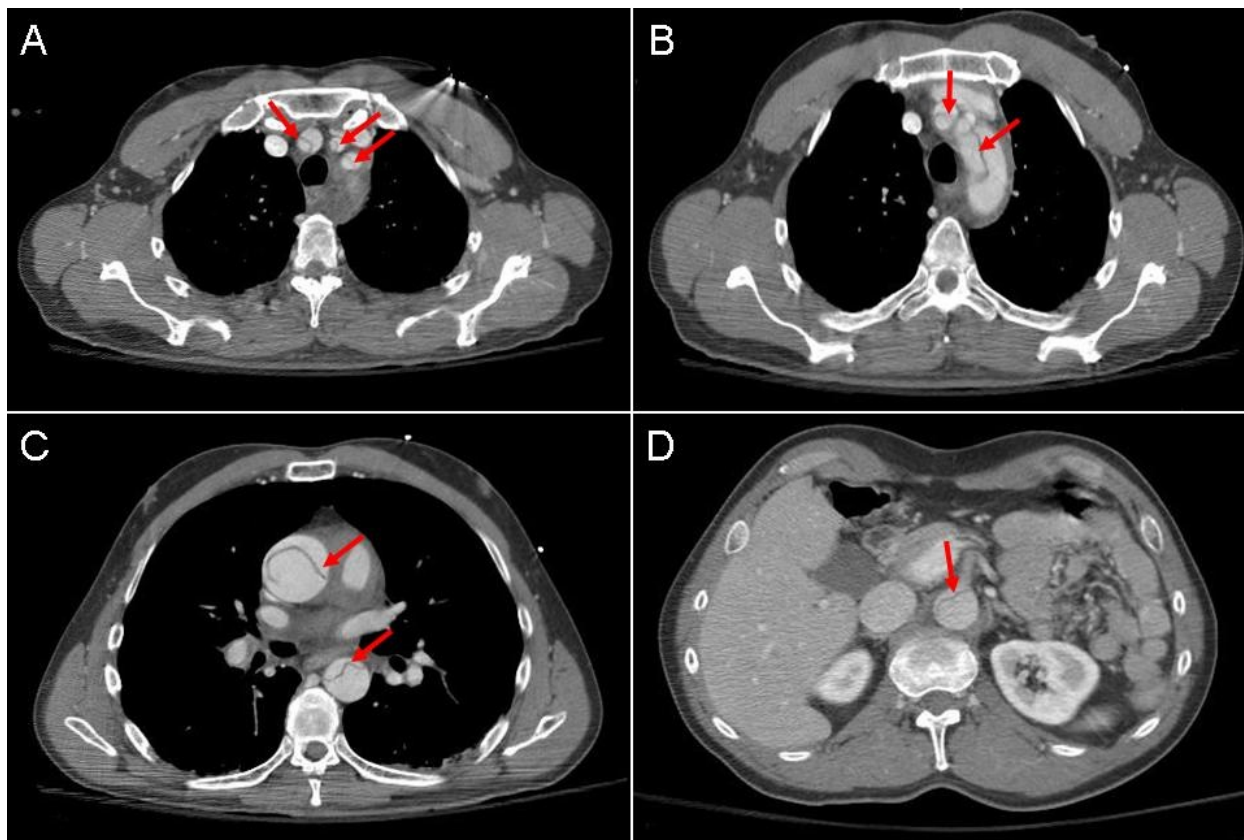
Contrast enhanced thoracic CT scan showing the arterial dissection separating the intimal and medial vascular layers (red arrows).
